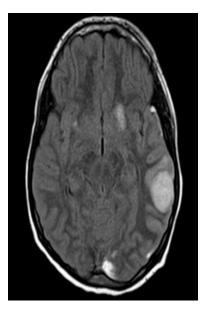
MRI Image of Case 2: Cortical Venous Thrombus, Sagital Sinus Thrombosis
